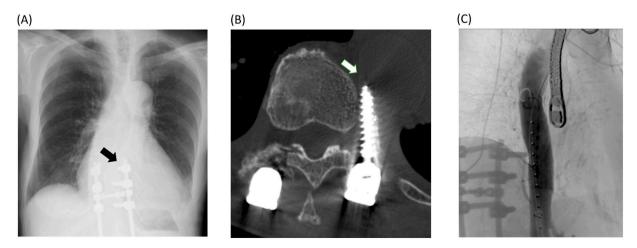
(A) Follow-up radiography showed that the upper leftmost screw was displaced from the vertebrae (arrow: displaced screw).(B) CT showed that the tip of the screw was pushing against the descending aortic wall and was probably encroaching on the outer membrane of the descending aorta (arrow: outer membrane of the descending aorta).(C) Aortography showed that the screw was pushing against the side of the aortic wall.
